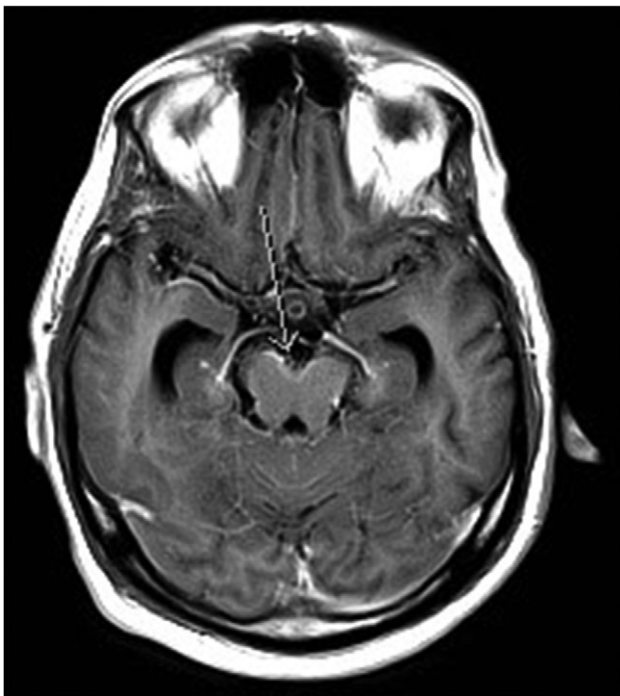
MRI brain T1 axial post contrast. Arrow indicates leptomenigeal enhancement in the interpeduncular cistern of the midbrain.
